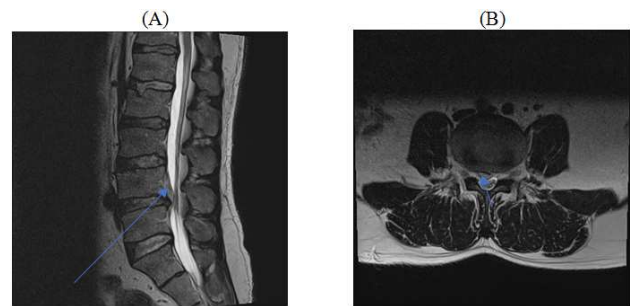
Lumbar spine MRI T2 sagittal (A) and axial (B) sequences.
